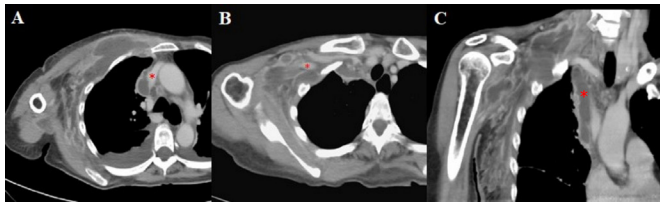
Axial views (A and B) and sagittal view (C) obtained from multidetector CT on hospital day 8. They demonstrate (A) large area of an abscess formation over inner part of the right upper chest wall, particularly the pectoralis muscles, which also compressed to the right lateral part of superior vena cava (star); (B) abscess compressed to distal end of the right subclavian vein (star); (C) abscess extended to right lower neck and mediastinum (star).
